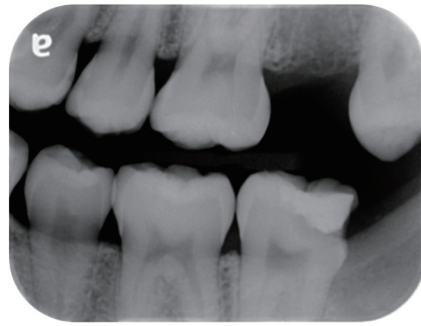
Bitewing film of tooth 37. Secondary caries was noted beneath the old restoration with proximity to the pulp.
